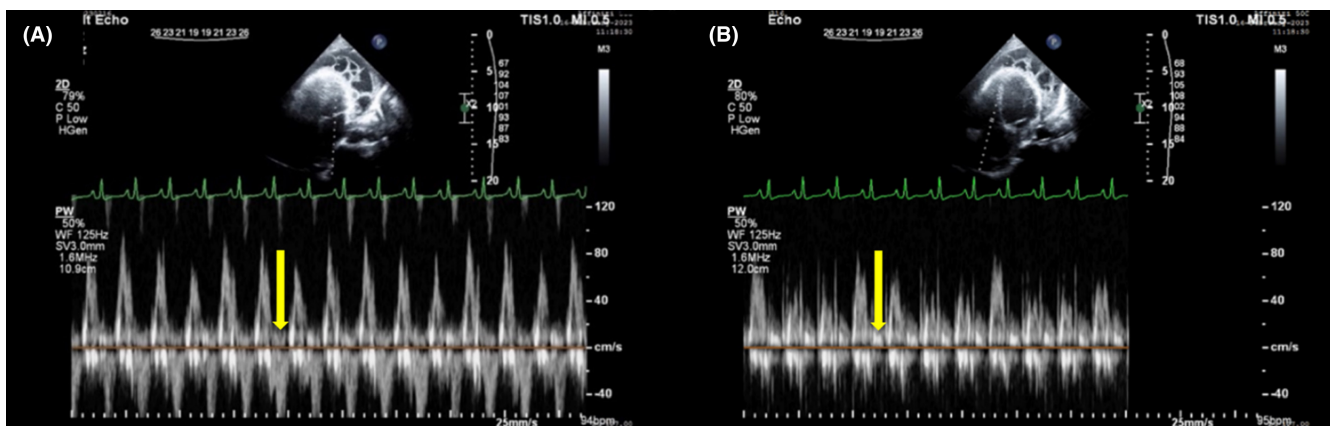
TTE imaging results. (A) Apical four-chamber view showed more than 40% respiratory variations of the mitral valve inflow E velocity. (B) Apical four-chamber view showed more than 50% respiratory variations of tricuspid valve inflow with inspiration. The yellow arrows point towards the respiratory variations.
